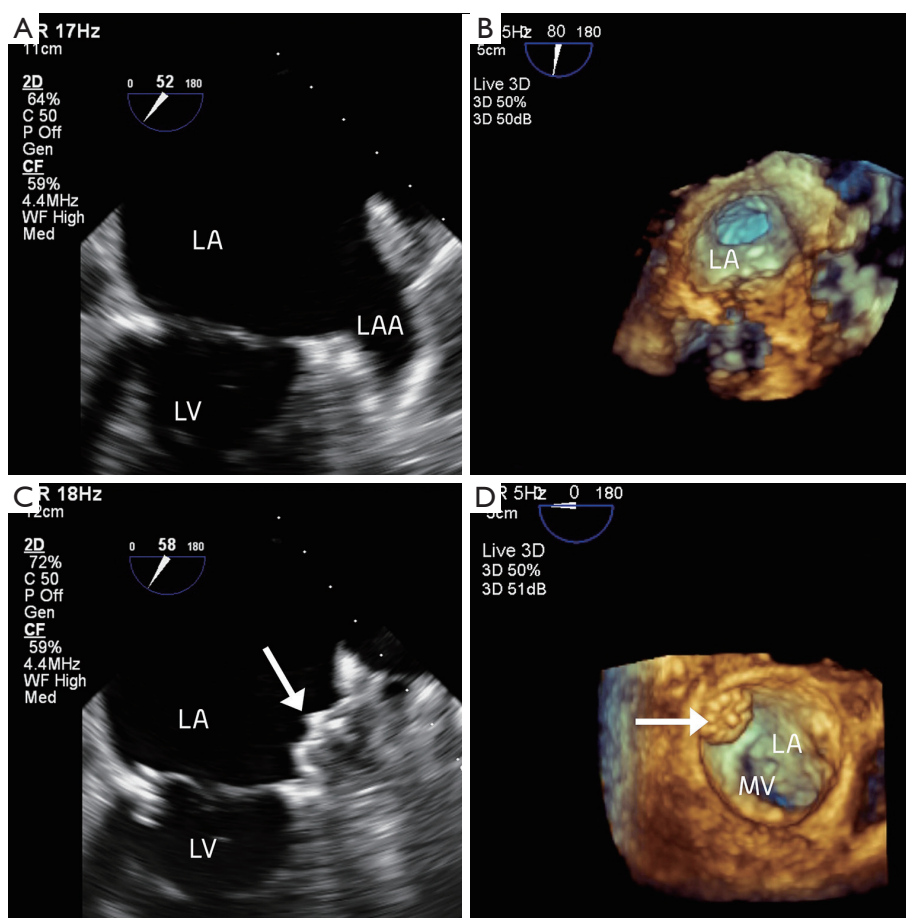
(A) 2D TEE of LAA, LA and LV before LAA closure; (B) 3D TEE of LAA and LA before LAA closure; (C) 2D TEE of LA, LV with the Watchman® closure device in the LAA; (D) 3D TEE of MV and LA with the Watchman® closure device in the LAA. 3D TEE, three dimensional transesophageal echocardiogram; LAA, left atrial appendage; LA, left atrium; LV, left ventricle; MV, mitral valve.
